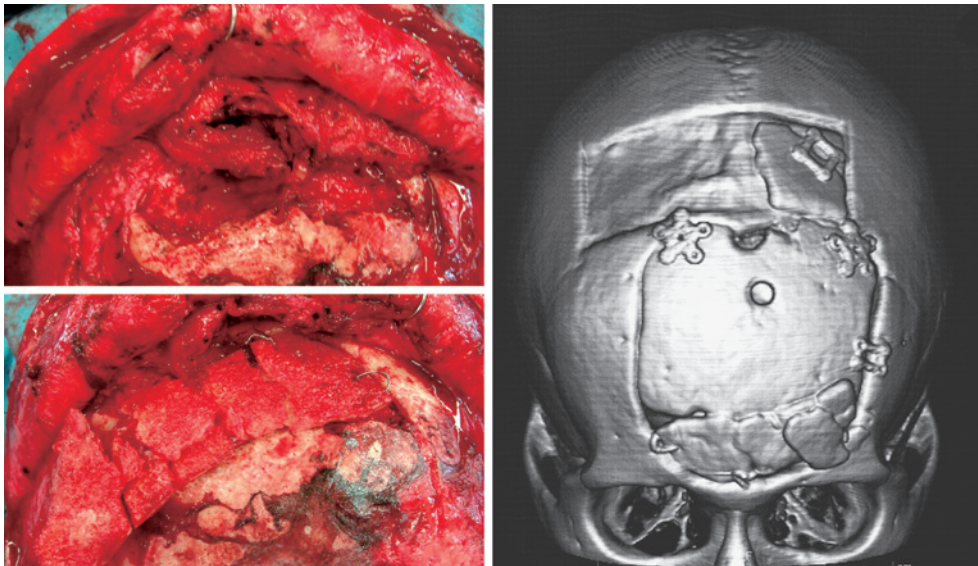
The frontal sinus is closed primarily with Gelform™ with fibrin glue, and the monopedic- cle galeal flap is isolating the frontal sinus from the epidural spaces (upper left) An inverted and segmented galea-calvarial flap covers onto this monopedic- cle galeal flap to doubly secure the isolation, and cranial reconstruction preserves the blood supply from the galea into the outer table of the calvaria (lower left). Note that the segmentation of the calvarial graft makes cranial reconstruction possible when the flap is reversed. Postoperative 3-dimensional computed tomography shows the proper use of a calvarial graft (right).
